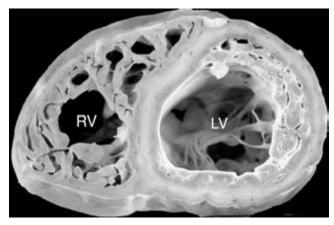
1 Myocardial noncompaction. Cine MR image of the ventricles in short axis shows tiny tracks between the fine trabeculations in the thickened myocardium of the free wall of the left ventricle (LV). RV, right ventricle.
